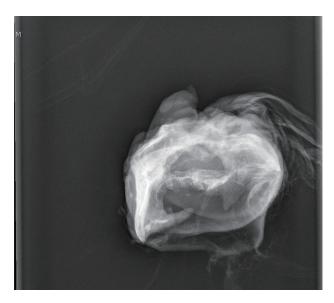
Plain X-ray showing embryonic vertebral column and long bones corresponding to fetal limbs.
